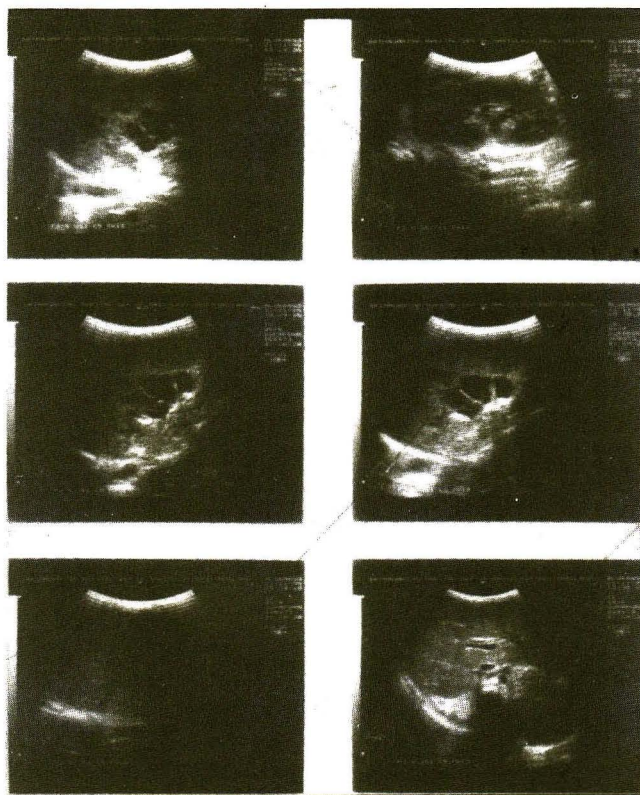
Abdominal ultrasonography showed multiple splenic abscesses.
